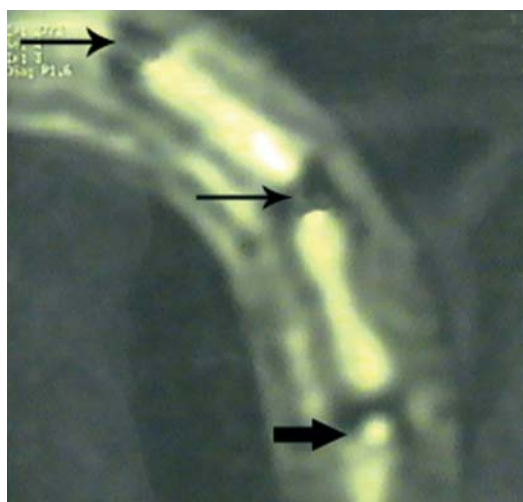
Magnetic resonance imaging 1 month after surgery. T2-weighted image. Thin arrows: degenerative and dystrophic changes in IVD caused by compression; thick arrow: IVD without compression (tissue hydrophilicity is preserved).
